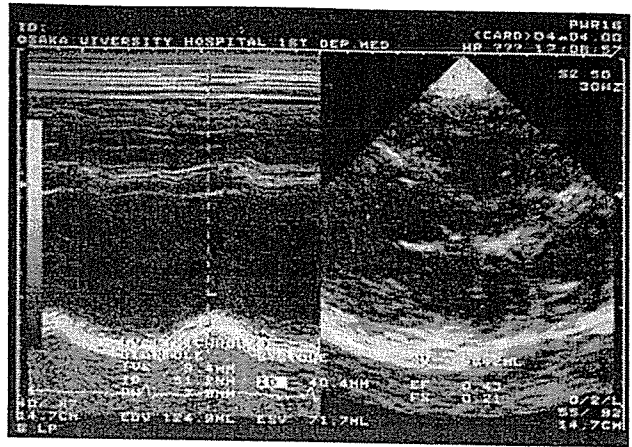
Echocardiography showed hypokinesis and hypostole of the left ventricle, congestion, and pulmonary hypertension. LVEDd (left ventricular end-diastolic diameter), 53 mm; LVEDs (left ventricular end-systolic diameter), 38 mm; IVST (interventricular septum thickness), 9.4 mm; PWT (posterior wall thickness), 7.8 mm; EF (ejection fraction), 43%; FS (fractional shortening), 21%; Δ PG (pressure gradient); 38 mm
